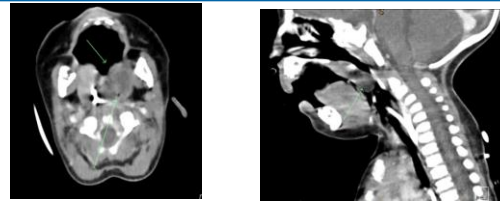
CT neck with contrast soft tissue
